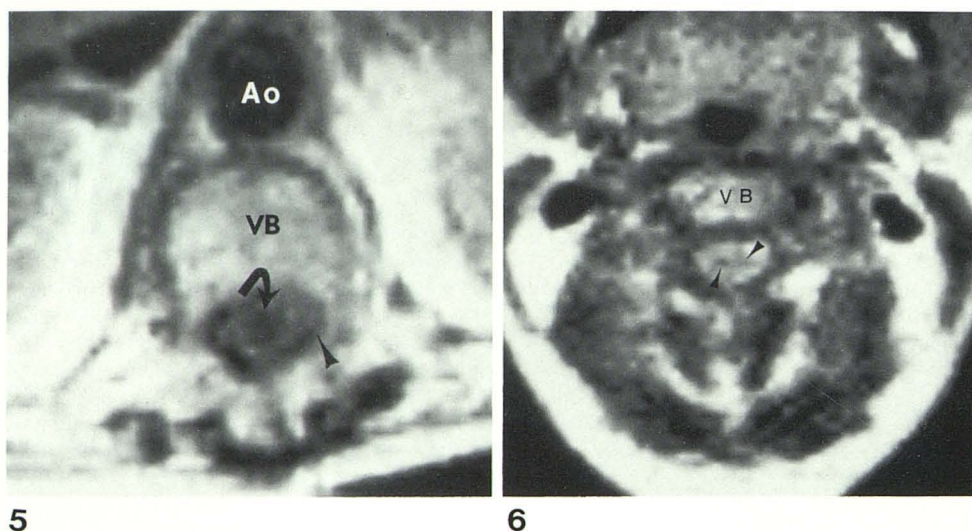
Axial spin-echo image. Lower thoracic syrinx (*curved arrow*) appears as round area of low intensity in enlarged thoracic cord. Margins of cord are somewhat irregular and poorly defined due to arachnoidal adhesions and scarring (*arrowhead*), which had previously appeared on myelography and metrizamide CT. VB = vertebral body, Ao = aorta.
